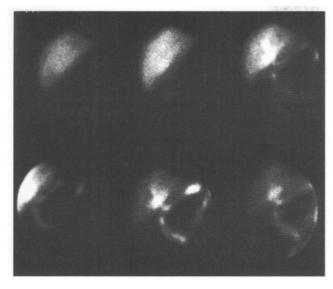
Cholescintigram with 99Tc-HIDA, for evaluation of a choledochojejunosomy function which works properly.
